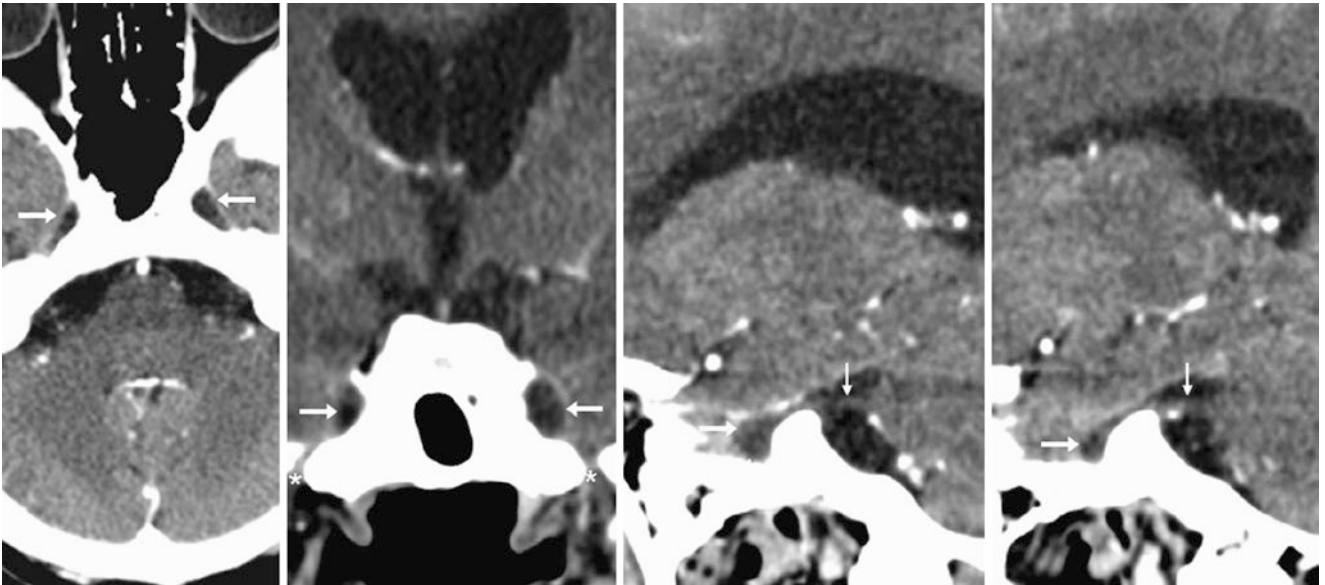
A 63-year-old patient with a contrast-enhanced CT (CECT) axial image (*left*) reconstructed from a CT angiography, demonstrating asymmetric prominence of the right Meckel cave as compared to the left (*arrows*). This is more evident on coronal reformats (*left middle*)
